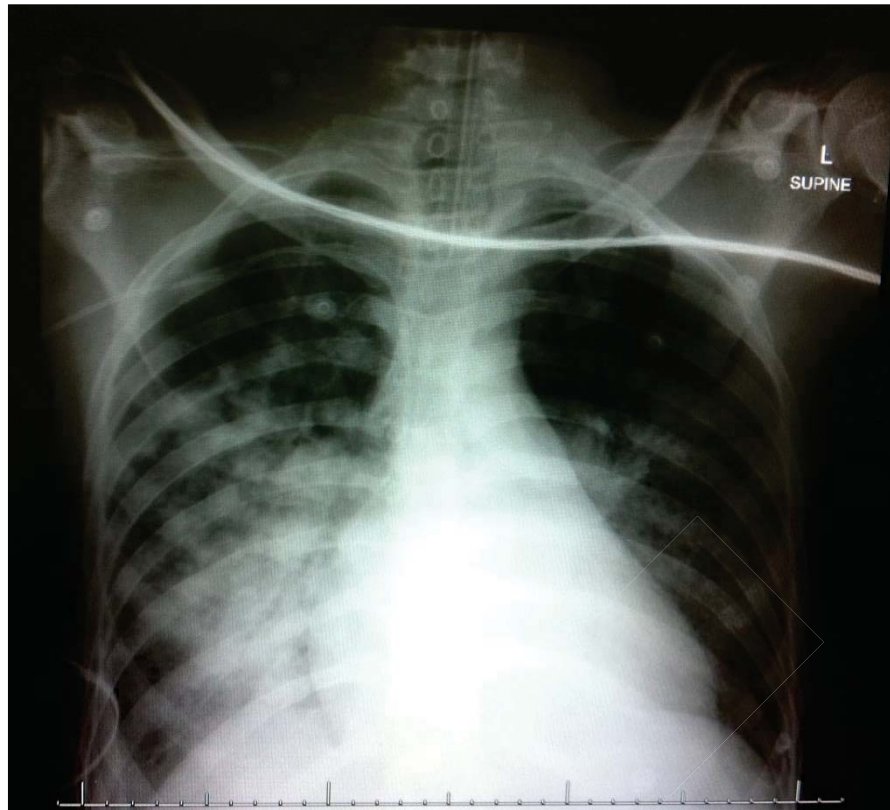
Chest Xray showing multi lobar pneumonia
